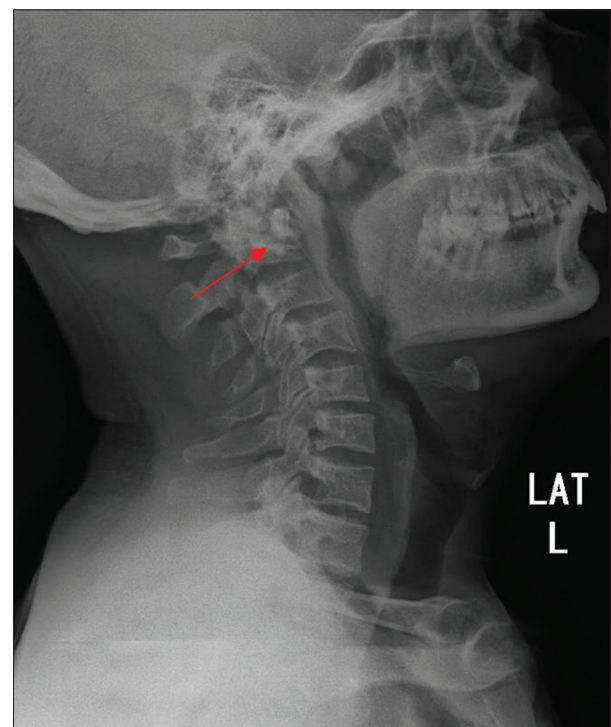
Lateral radiographic view of cervical spine showing upward migration of the odontoid process (red arrow), suggestive of basilar invagination
